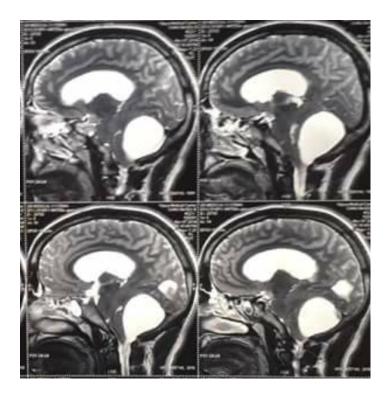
T₂-weight image MRI showing retro cerebellar arachnoid cyst
